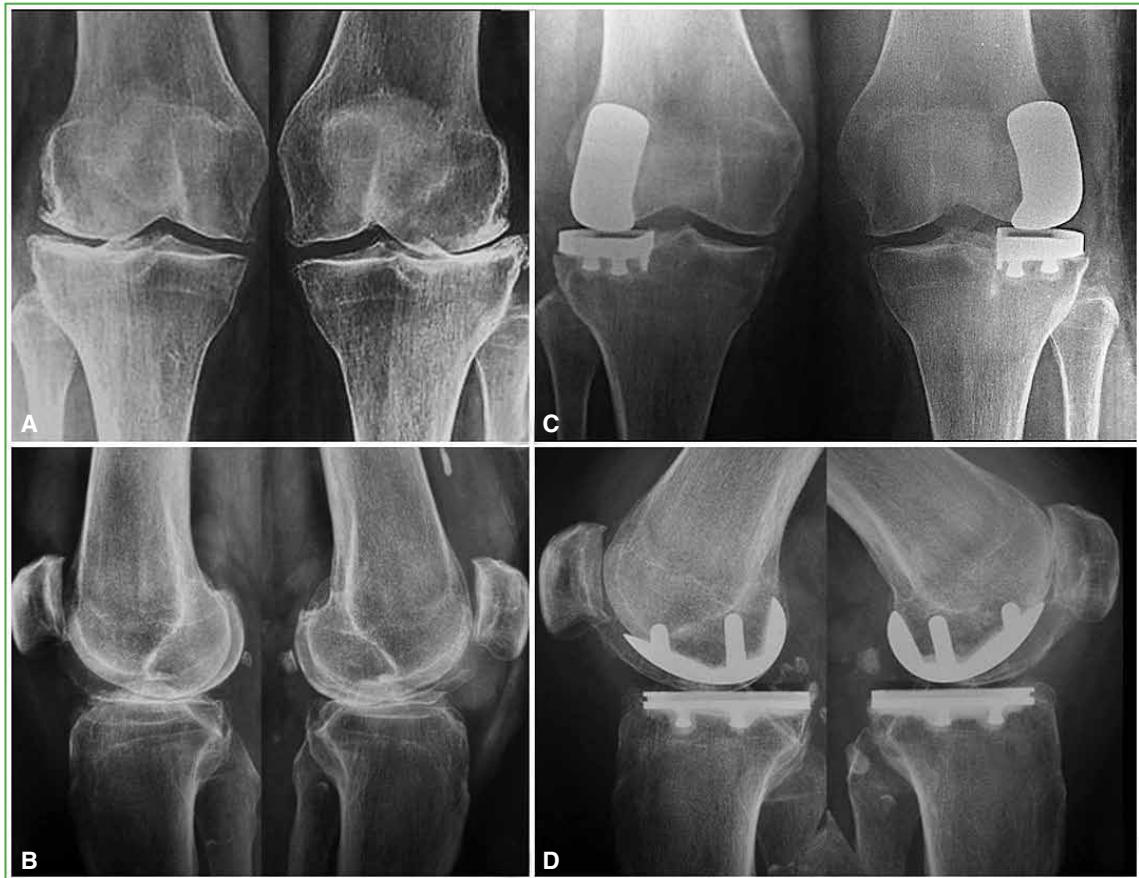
Preoperative (A and B) and postoperative (C and D) anteroposterior and lateral radiographs of both knees. Patient with bilateral lateral unicompartmental prosthesis and 7.2 years of follow-up.
